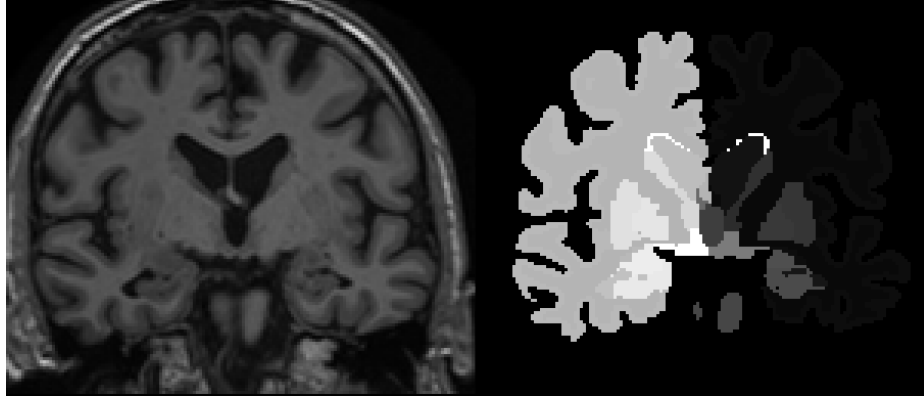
A coronal slice of a T1 weighted MRI scan (left) and segmentation (right) generated via Freesurfer.
